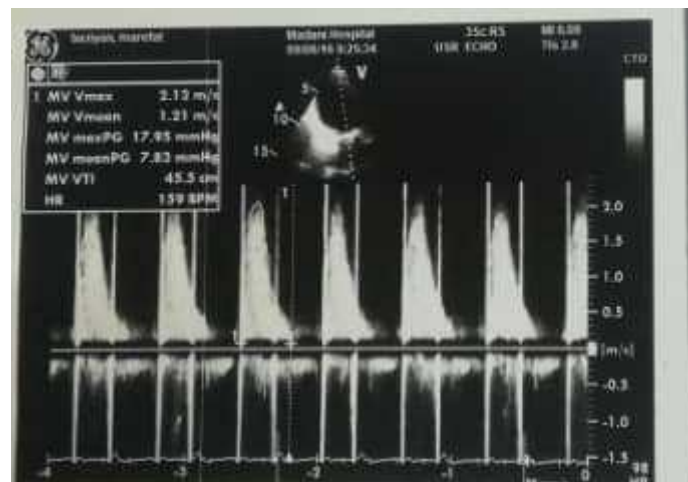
Postoperative Doppler echocardiography
